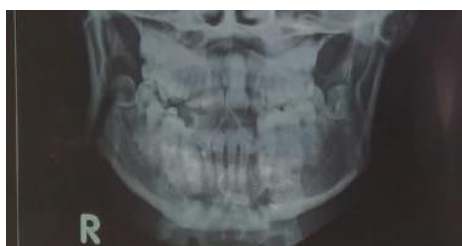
pre operative NCCT face x-ray
